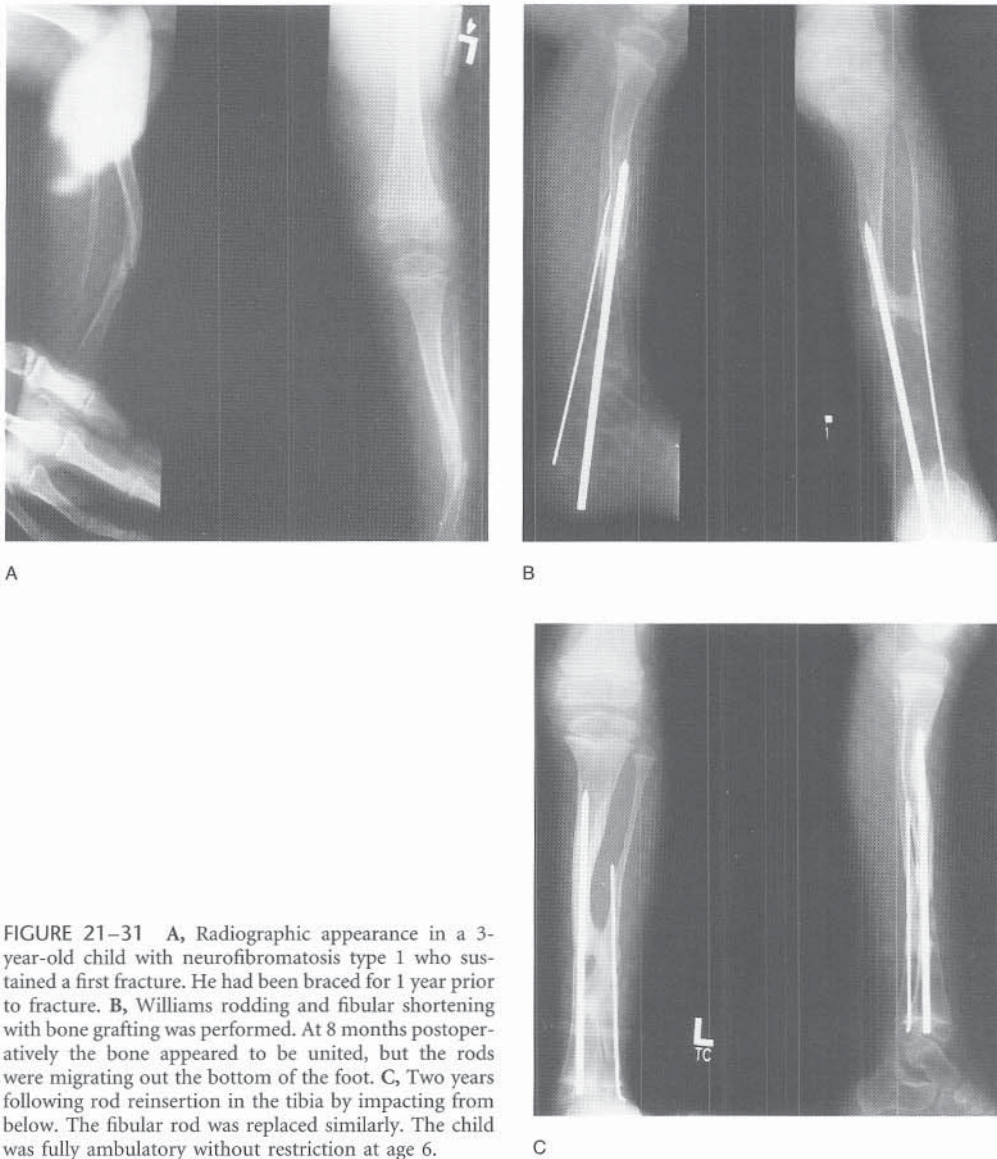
A, Radiographic appearance in a 3-year-old child with neurofibromatosis type 1 who sustained a first fracture. He had been braced for 1 year prior to fracture. B, Williams rodding and fibular shortening with bone grafting was performed. At 8 months postoperatively the bone appeared to be united, but the rods were migrating out the bottom of the foot. C, Two years following rod reinsertion in the tibia by impacting from below. The fibular rod was replaced similarly. The child was fully ambulatory without restriction at age 6.
